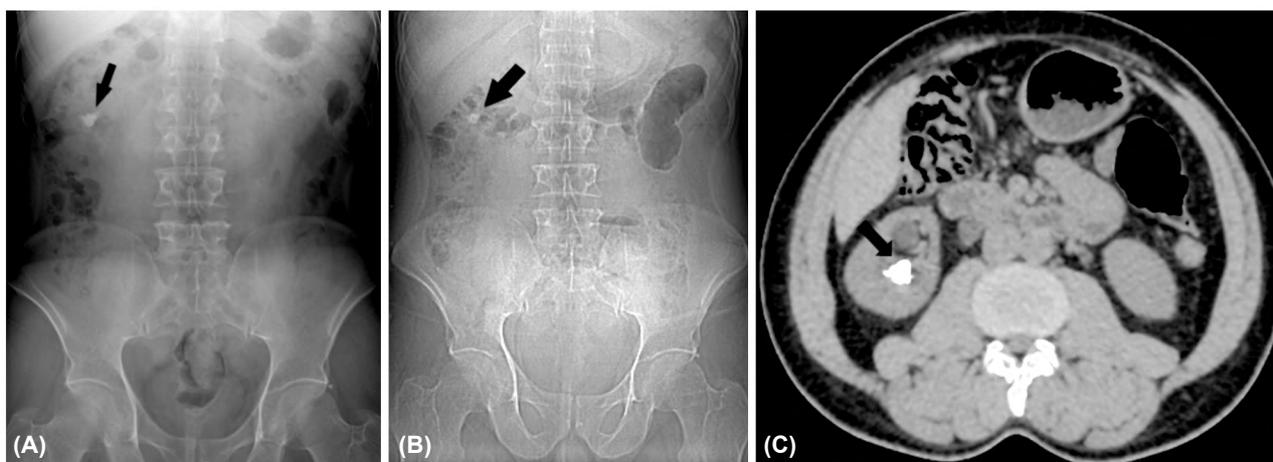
Left kidney stone visible on all three images-KUB, CT scou and CTUT 17x13mm size, 1700 HU.
